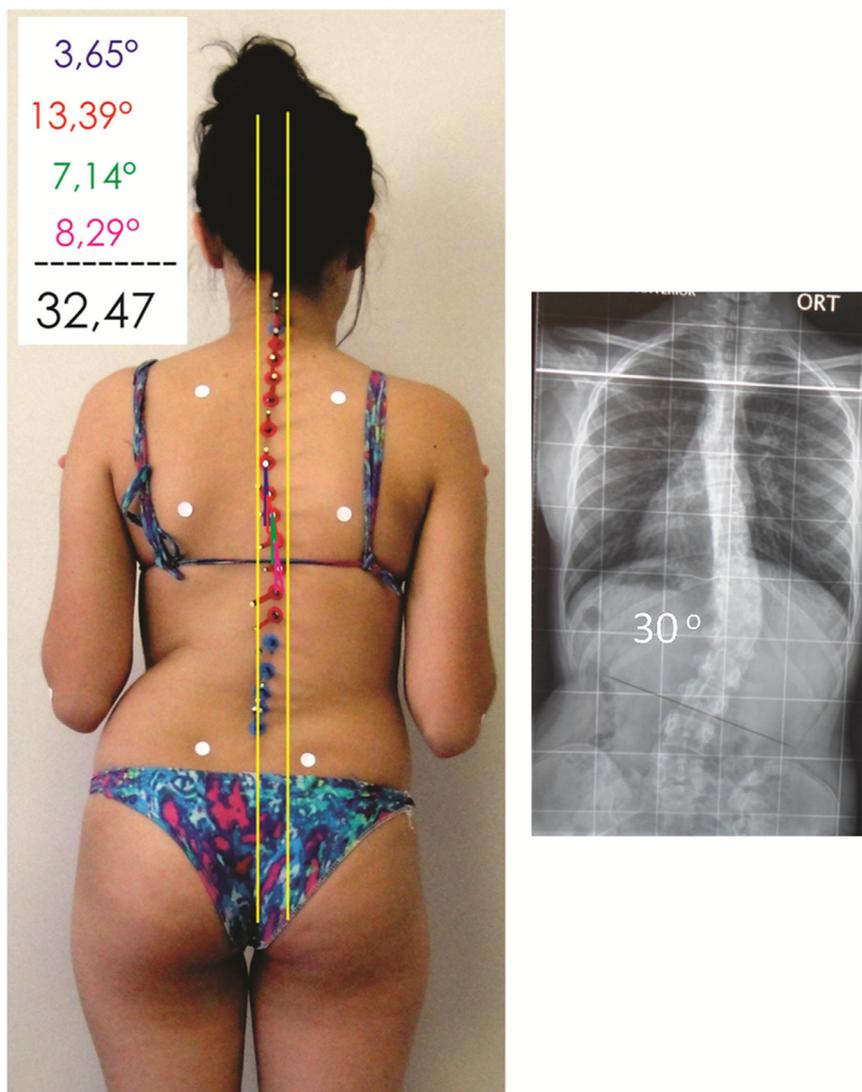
Measurements of the curve in a typical case obtained through both photogrammetry and radiography. Photogrammetric method=32.47°. Cobb radiographic method=30°.
